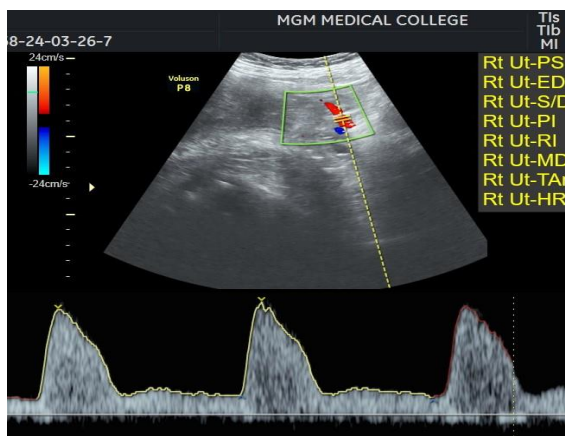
Abnormal uterine artery Doppler wave form demonstrating high resistance
